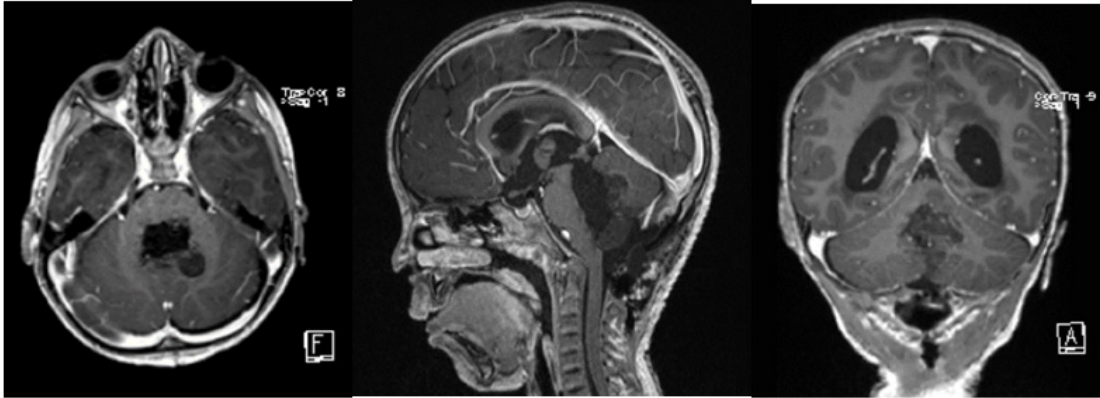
Post-operative MRI Day 1: No residual.
